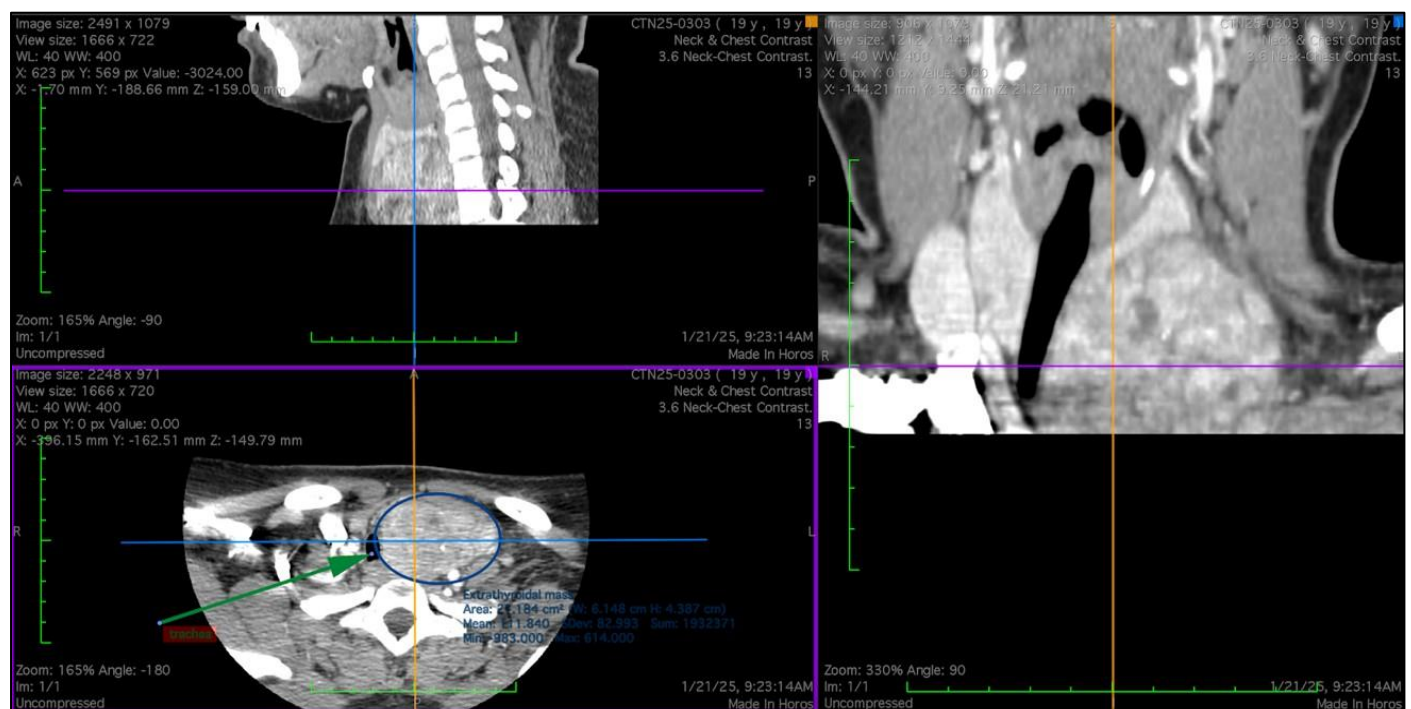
Neck and Chest CT with IV Contrast Imaging Demonstrating a Heterogeneously Enhancing Mass Adjacent to the Left Thyroid Lobe Extending to the Thorax
